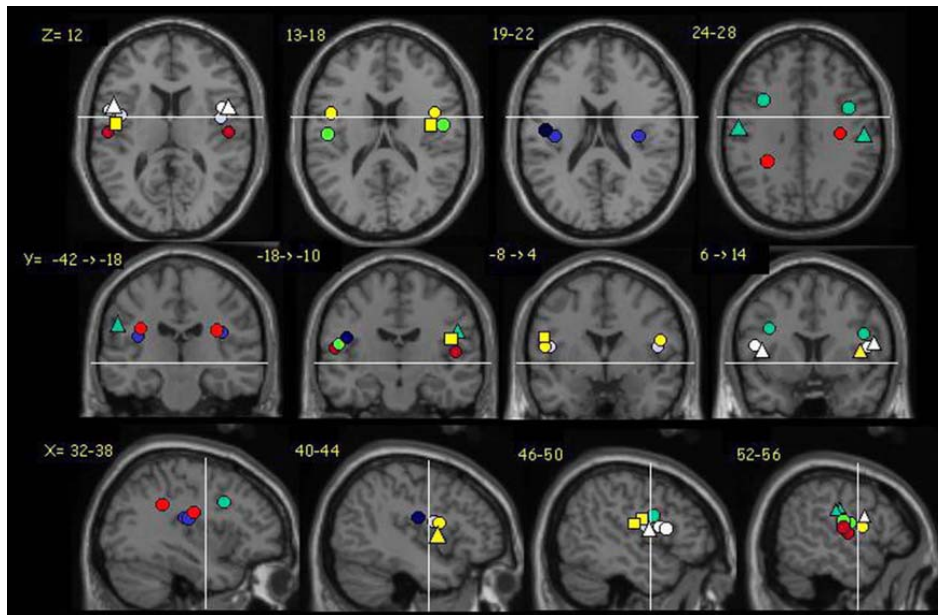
Anatomical locations of suprasylvian laser-evoked potential sources reported in twelve studies were projected onto a 3D-MRI normalised in Talairach space. White lines cross the anterior commissure in axial, sagittal and coronal slices. Although inter-study variability was important in the anterior-posterior axis, the overall distribution of sources closely followed the axis of the Sylvian sulcus. Pale blue circles and yellow triangles represent data from intracranial recordings. From Garcia-Larrea et al., 2003.
